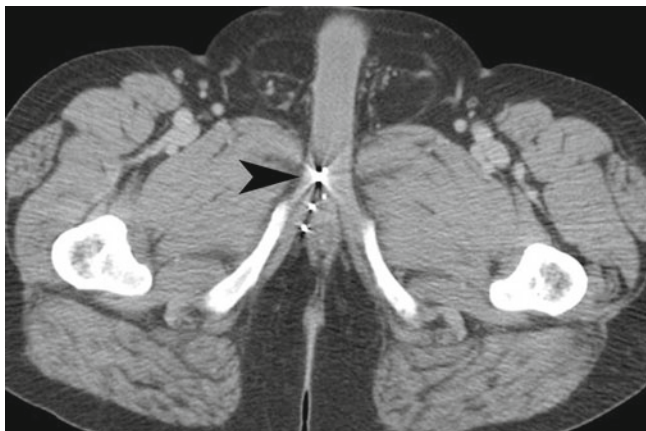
Penile and urethral injury from shotgun pellets. Contrast-enhanced CT demonstrates multiple metallic foreign bodies (*arrowheads*) in the corpora cavernosa and spongiosum of the penis
